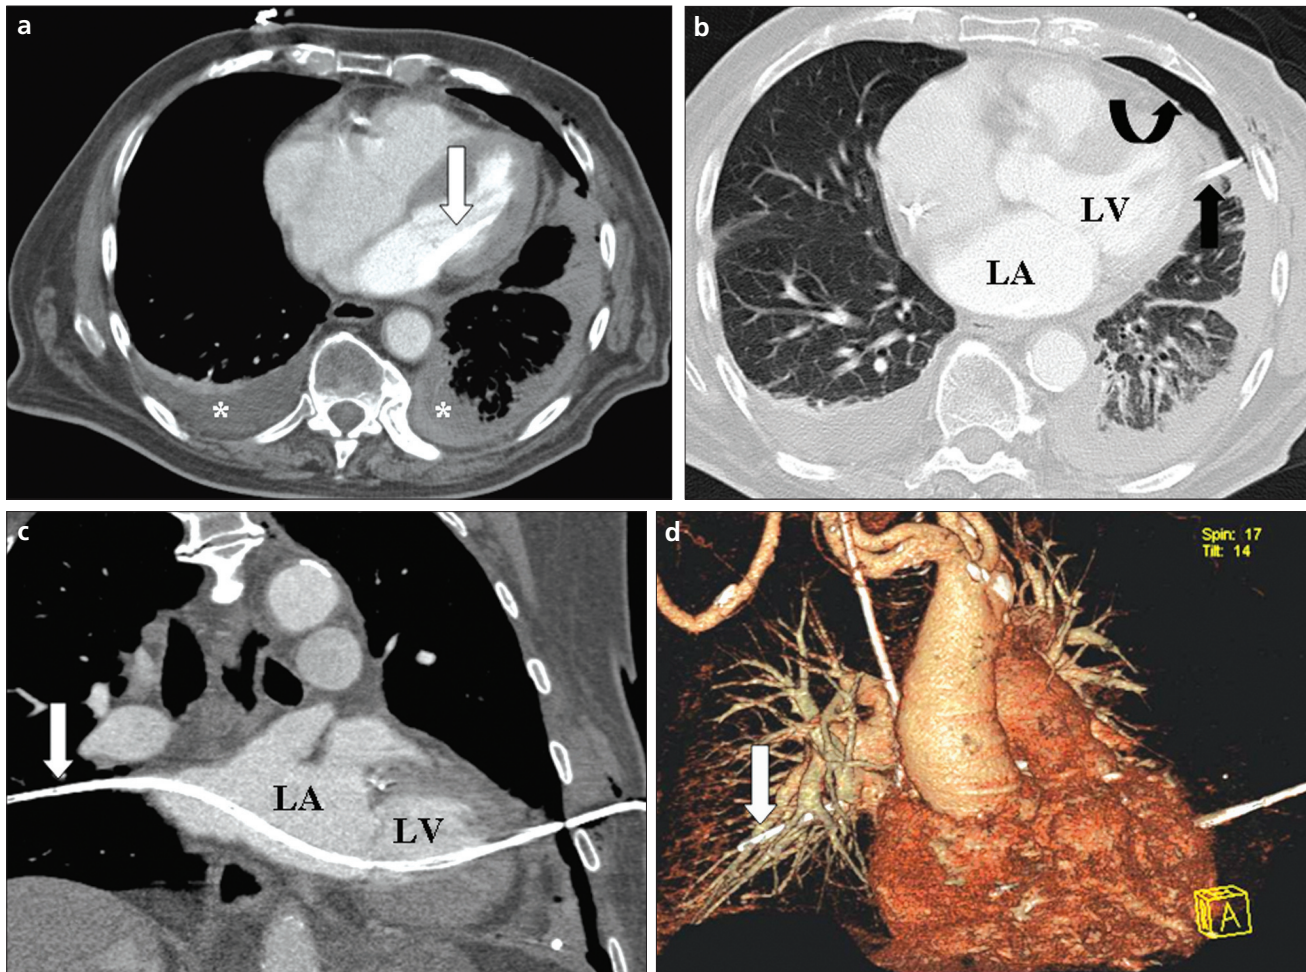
a–d. Mediastinal window axial CT (a) with the pleural drainage (white arrow) passing through the mitral valve; there are bilateral pleural effusions (asterisks). Lung window axial CT (b) with a small pneumothorax (curved arrow) and the drain penetrating the myocardium of the left ventricle (LV). Curved multiplanar CT reconstruction (c) along the pleural drain (white arrow) highlights the course of the drain through the left ventricle and atrium (LA) and the tip placed in the middle lobe. Oblique coronal volume-rendering 3D reconstruction (d) showing the entry and exit of the drain (arrow).
